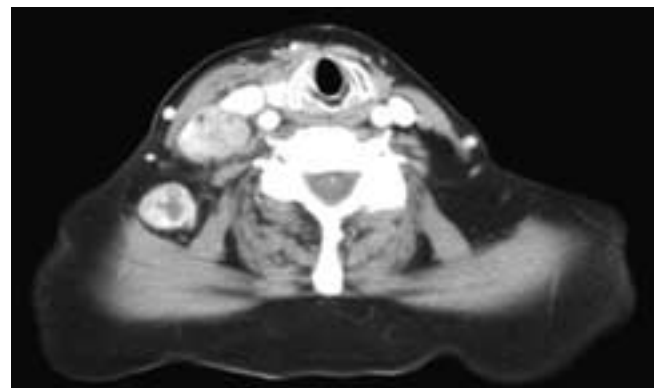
Axial contrast-enhanced CT scan shows a right level III enlarged, nonhomogeneously enhancing metastatic node. There also is an enlarged, enhancing, partially necrotic right level V node in this patient with metastatic squamous cell carcinoma.
